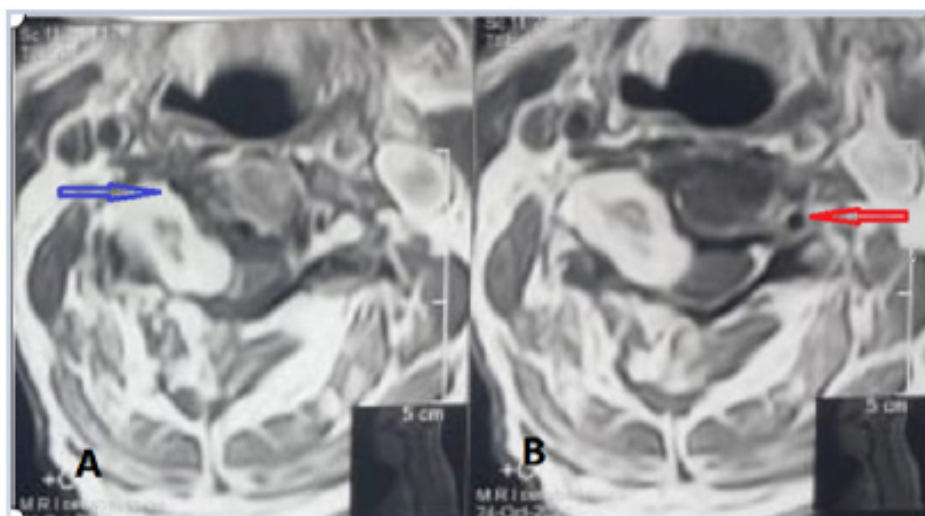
Axial cuts of MRI cervical spine with contrast of one of the study cases, (A) the blue arrow demarcating the displaced compressed vertebral artery, (B) the red arrow demarcating the position of vertebral artery at normal side.
